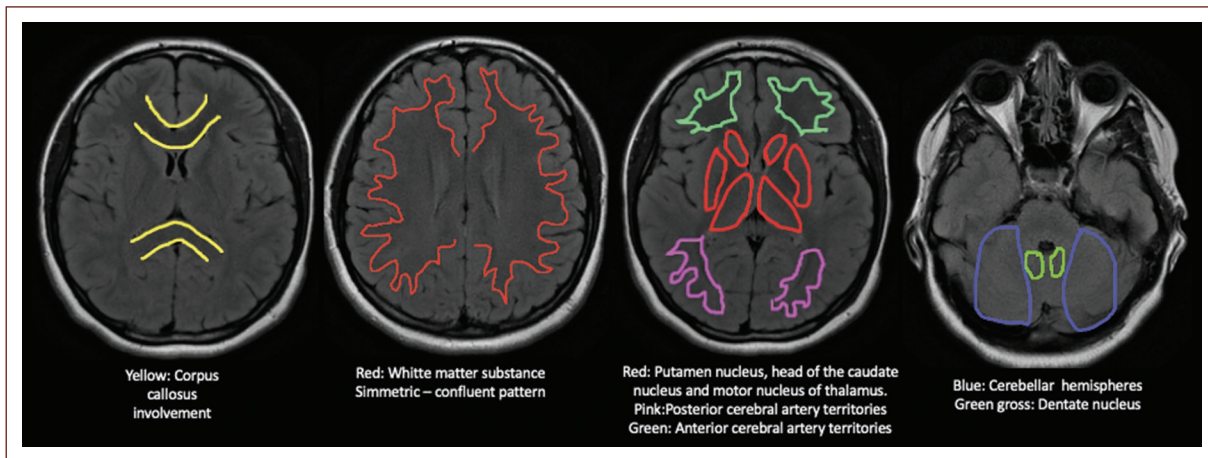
Images from T2 to T2-weighted magnetic resonance imaging show different patterns of injury on subcortical structures (white matter, basal ganglia, cerebellum, and watershed arterial territories). These images are not pathognomonic for opioid use intoxication, which will be seen in other toxic-metabolic states from many etiologies, but suggest the possible role of opioids in brain damage²⁴⁻³⁰. Modified with Biorender.com.
